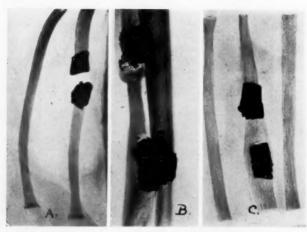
A. A section of radius 5.8 cm. long was excised subperiosteally. No attempt was made to remove the tiny particles of bone, which may have adhered to the line of muscle attachment. X-ray taken 31 days later. Note new bone along line of bone particles. B. The entire radius, including the articulating surfaces, was removed subperiosteally. No visible bone particles were allowed to remain. X-ray taken 129 days later. No new bone formation could be made out. C. Control. D. Extent of regeneration of a rib after a partial subperiosteal resection of 2.8 cm. X-ray taken 87 days later. The growth is only from the rib ends. E. Extent of regeneration of a rib after partial subperiosteal resection of 2.1 cm. X-ray taken 105 days later. The irregular growth is from the rib ends. The periosteal tube was not closed in either D or E. F. The regeneration of a rib after partial subperiosteal resection of 3 cm. X-ray taken 100 days later. The periosteal tube was closed and the growth from the rib ends has followed the tube.
